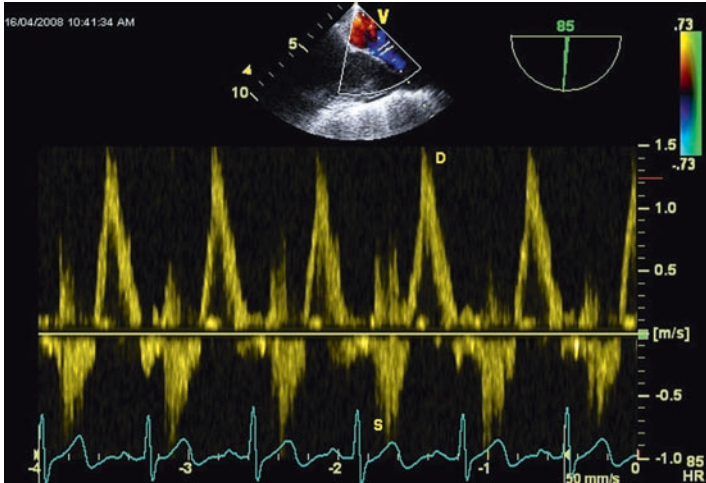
Pulsed wave Doppler of pulmonary vein flow demonstrating systolic flow reversal (S) followed by very dominant early diastolic forward flow (D). This suggests severe mitral regurgitation.
